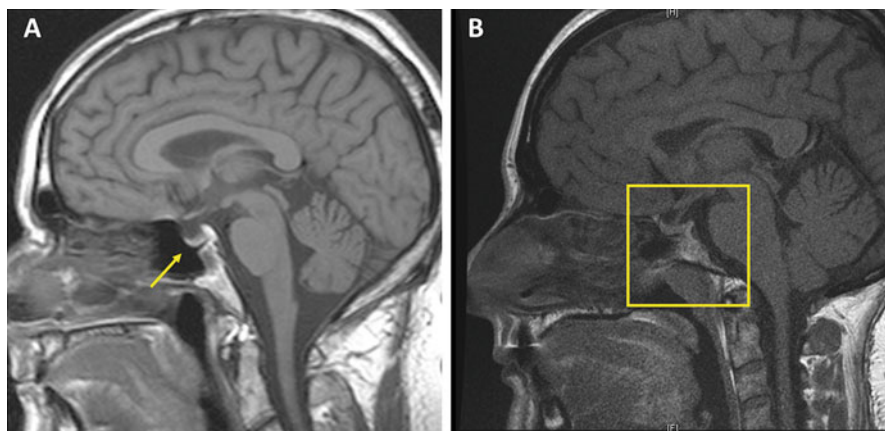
Magnetic resonance imaging (MRI) showing the bright spot in a normal patient (a, pointing arrow) and its absence in a patient with central diabetes insipidus (b, square)
